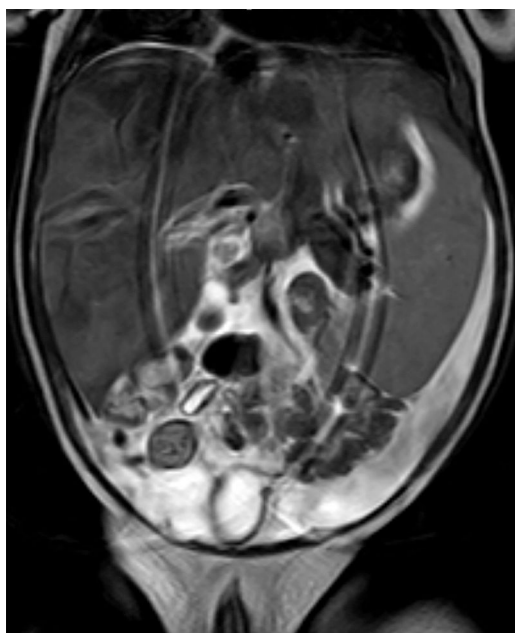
MRI image of the patient in which moderate–severe hepatomegaly and splenomegaly can be seen.
